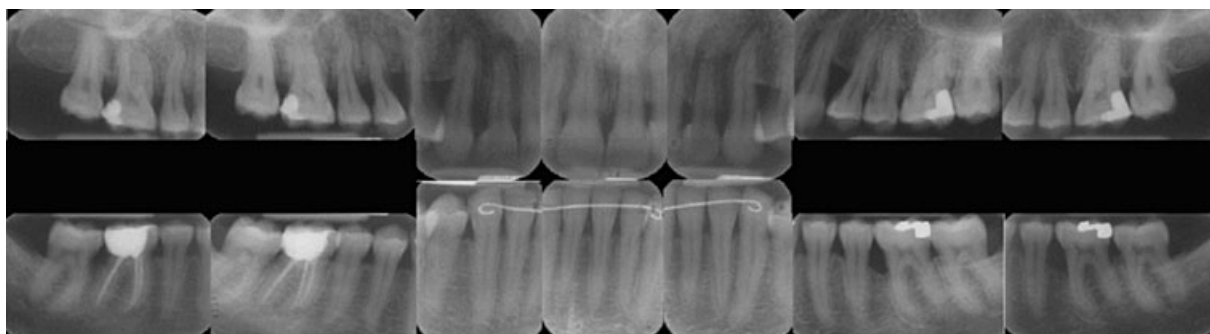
Radiographs of the patient presented in Fig. 31-2 at the final re-evaluation.
